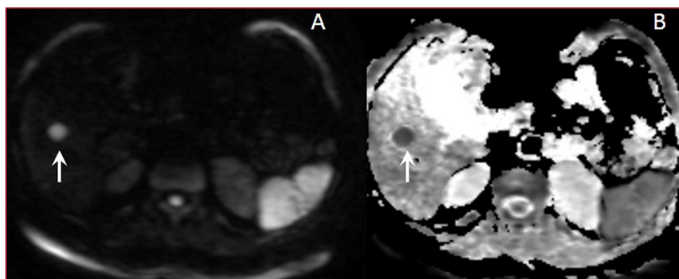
The metastatic mass lesion observed in liver parenchyma A) Diffuse hyperintense appearance in DWI; B) Diffuse hypointense appearance in ADC map passing through the same section
